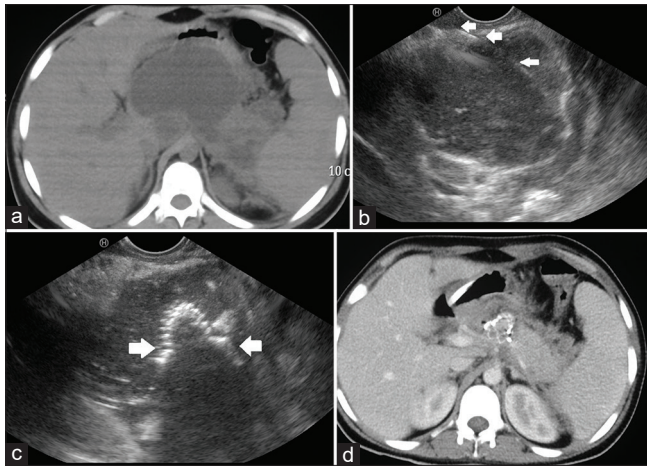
(a) Computed tomography: Large necrotic collection with encapsulating wall. (b) EUS guided drainage of pancreatic necrosis. Guide wire (arrows) seen in the predominantly solid collection. (c) BFMS placed into necrotic collection. On EUS inner opened flange of BFMS noted (arrows). (d) Computed tomography: Resolved WON with BFMS *in situ*. BFMS: Bi-flanged fully covered self-expanding metallic stent; WON: Walled-off necrosis
